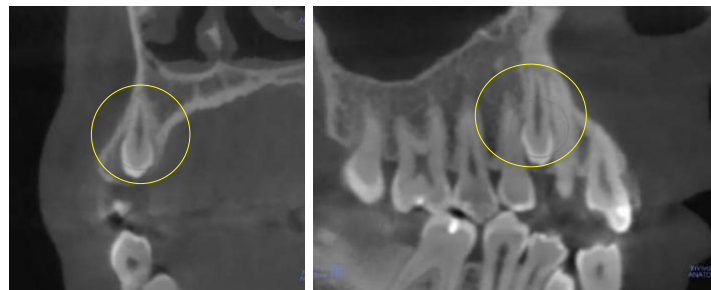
Coronal (left) and sagittal (right) CBCT cross-sections showing supernumerary tooth #5A is unerupted and vertically oriented at the palatal aspect of teeth #5 and 6
